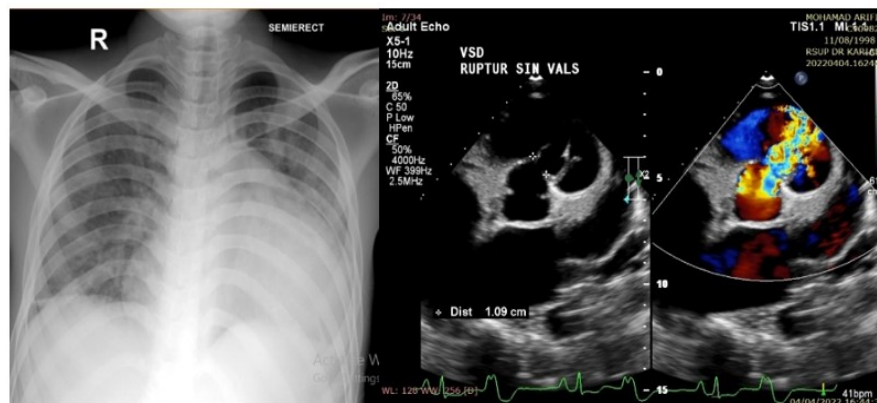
Left picture, showed chest x-ray. Right picture, echocardiography showed vsd with rupture of sinus valsava.
